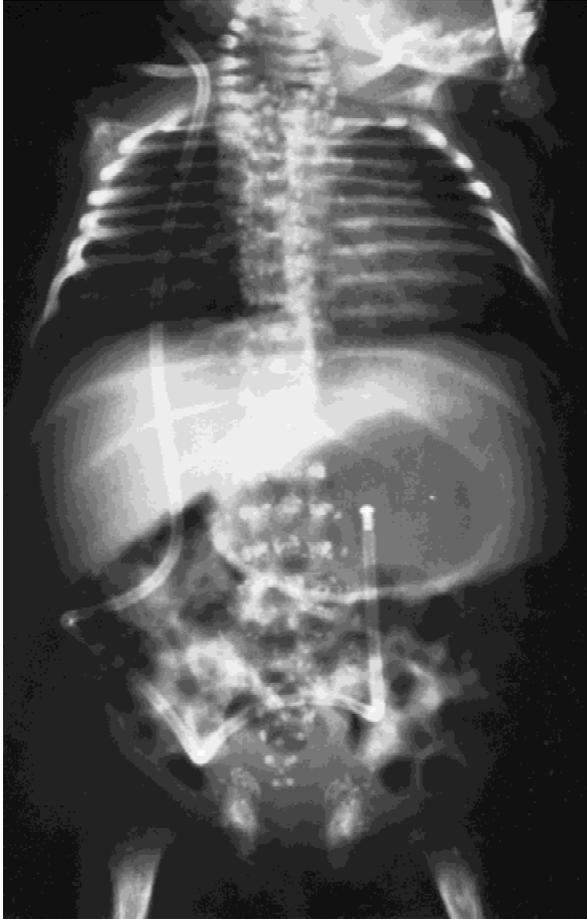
Radiograph of patient 1 at age 4 weeks. Radiodense stipplings are visible adjacent to the entire vertebral column, in the sacral and coccygeal region, adjacent to the public and ischial bones and proximal femoral bone ends. There is lack of fusion of the vertebral arches from C3 to C7. The chest is short and broad and the ribs are horizontal. A right-sided ventriculoperitoneal shunt system was implanted.
